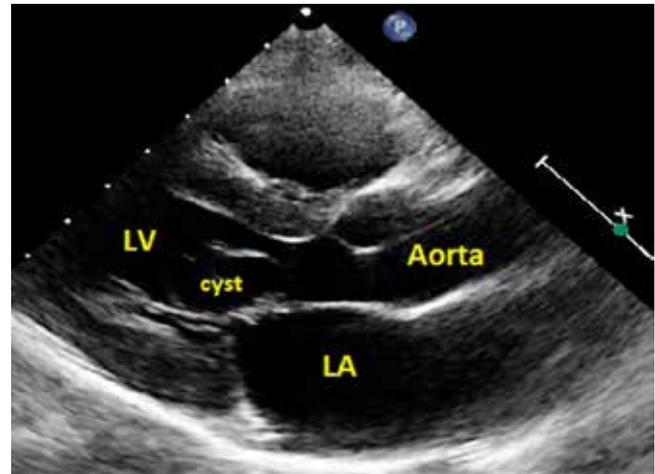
Transthoracic echocardiogram – parasternal long axis view. Blood cyst obstructing left ventricle outflow tract
